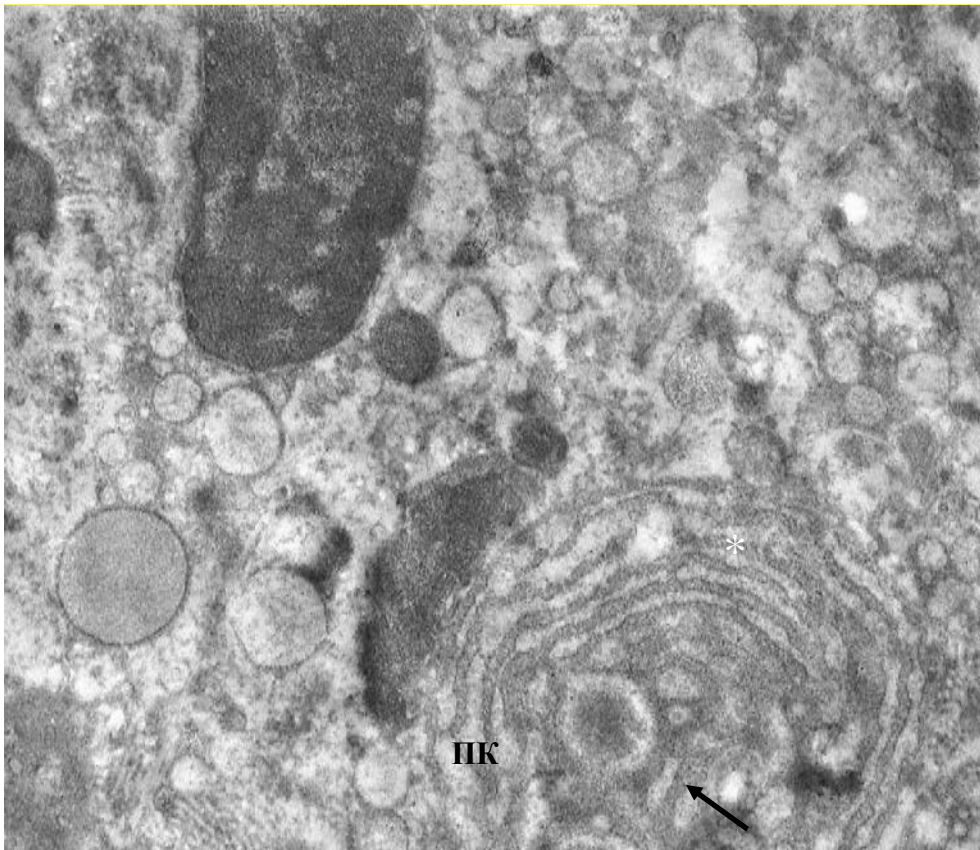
Plot of the plasma cell (ПК) within the periapical granuloma in patients with primary chronic granulomatous periodontitis. Low activity of the nucleus, insignificant osmiophily of "light court" (arrow). Moderate synthetic activity of granular reticulum. x8000.
